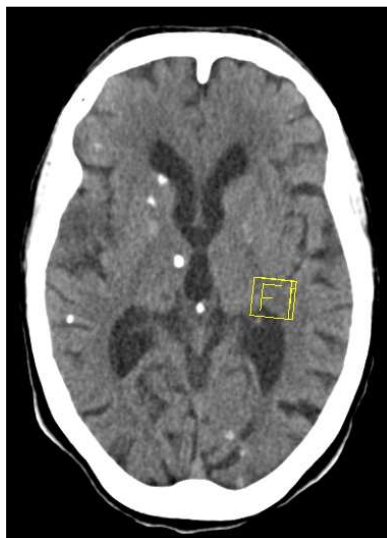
Neurocysticercosis type 2 and type 3. Patient, F/68, with slurred speech. Non-contrast brain CT shows multiple calcified nodules and non-calcified nodules. A type 2, target type, lesion is noted in the right temporal lobe with surrounding edema. Multiple partially calcified nodules are noted in the right frontal lobe and left occipital lobe. Differentiation with ischemic infarct of the right temporal lobe is difficult in CT.
